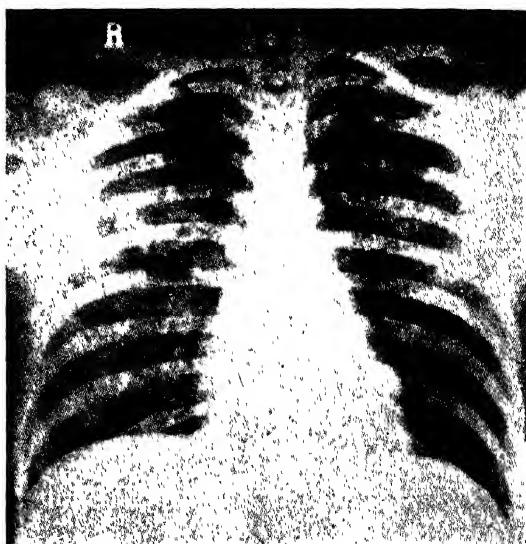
Early "wire-grass" type infiltration characterizing midresolution. (A. E. Seeds and M. L. Mazer : Am. J. Roentgenol.)
